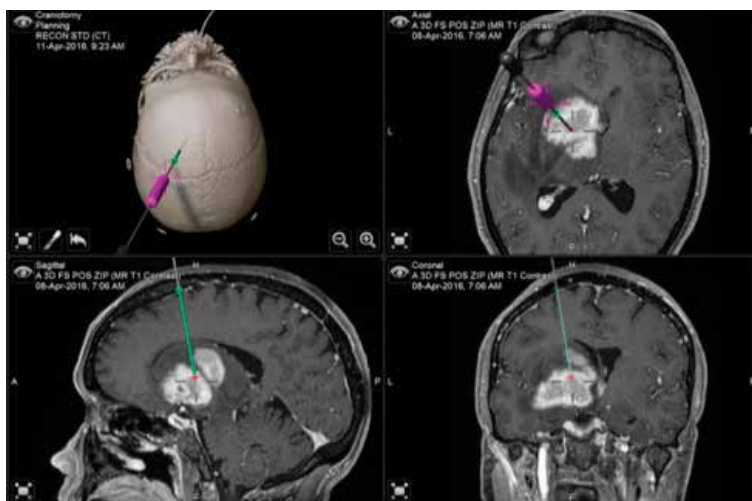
MRI of a frameless-based biopsy (neuronavigation guided) of a deep-seated lesion. Trajectory planning without any passage through ventricular system to avoid CSF drainage and brain shift.
